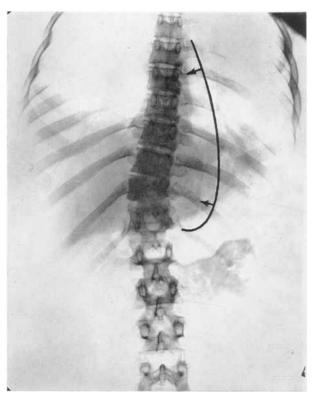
CASE 5. X-ray photograph of spine 3 weeks after delivery. The arrows show the increased extent of the paravertebral abscess.
